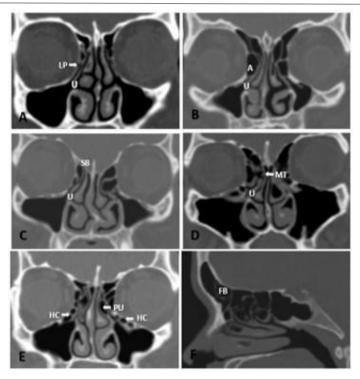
Plain CT of PNS coronal section: A) Type I (direct) attachment of uncinate process (U) to the lamina papyracea (LP) on right side; B) Type I (indirect) attachment of uncinate process (U) to the lamina papyracea through agger nasi cell (A) on right side; C) Type II attachment of uncinate process (U) to the skull base (SB) on right side; D) Type III attachment of uncinate process(U) to the middle turbinate (MT) on right side; E) Pneumatization of uncinate process (PU) on left side. Haller cells (HC); F) Plain CT of PNS sagittal section shows frontal bullar cell (FB).
